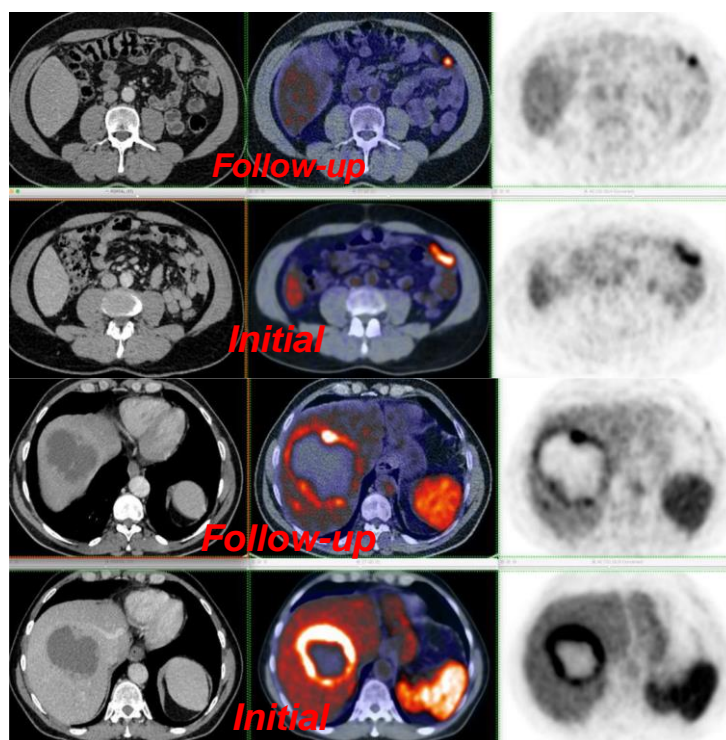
^{68}Ga - DOTATATE PET/CT to exclude the recurrence of a 65-year-old male patient with known GIT NET. A) Showed DOTATATE avid hepatic lesion, B) showed DOTATATE avid porta-hepatis node, C) DOTATATE avid peritoneal lesion. The patient received 2 cycles of ^{177}Lu DOTATATE therapy. Post-therapy PET/CT revealed regression of the previously detected DOTATATE avid lesions.
